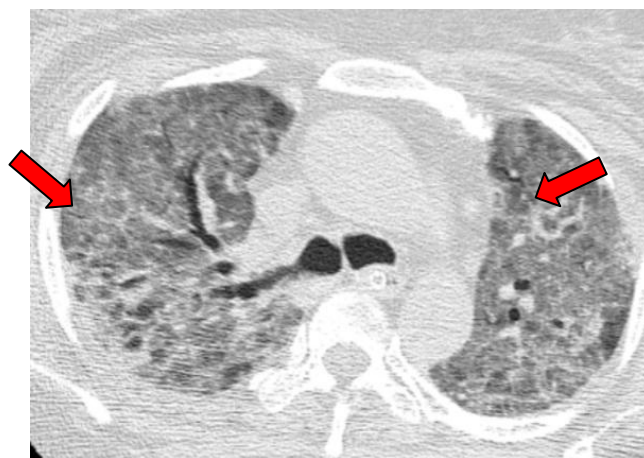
HRCT thorax of a 45 year old diabetic male patient shows areas of ground glass opacities with interlobular septal thickening (arrows) and adjacent fibrosis in bilateral lung fields
